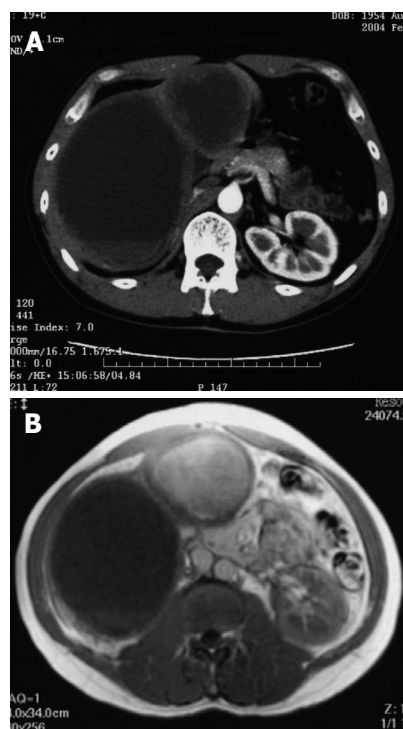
Contrast-enhanced CT scan (A) and MRI (B) on T1-weighted image 107 mo after the initial operation.
